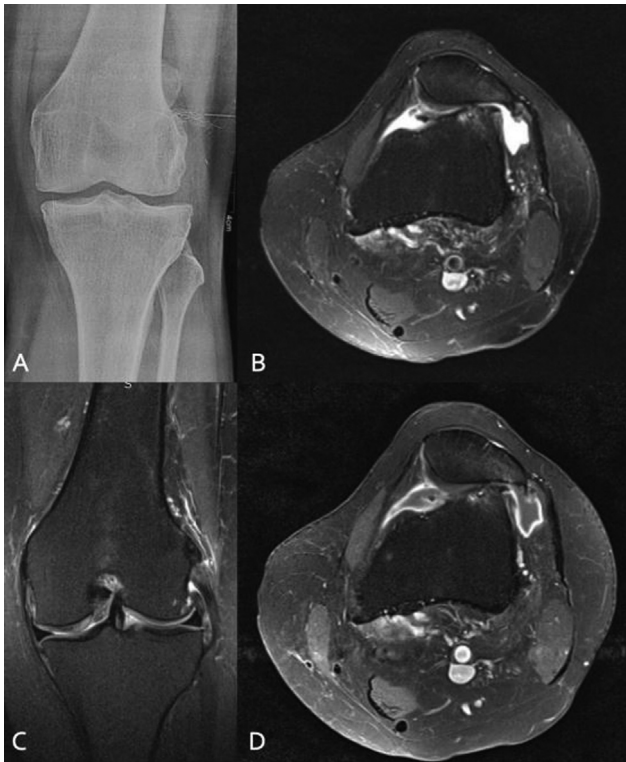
A 59-year-old female with right knee pain. (A) X-ray right knee (anteroposterior view) showing reduction of joint space (medial > lateral) with marginal osteophytes. (B) Proton density (PD) fat-saturated coronal image showing cartilage loss and exposure of subchondral bone in the medial femoral condyle and medial tibial plateau. (C) PD fat-saturated sagittal images showing reactive joint effusion, patchy marrow edema in medial femoral condyle (D). Postgadolinium T1-weighted axial image showing synovitis.
